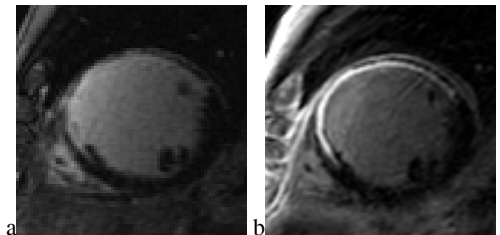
DE-MRI acquired with a) 2DBH and b) 3DNAV. 3DNAV provides substantially better delineation of infarct.
